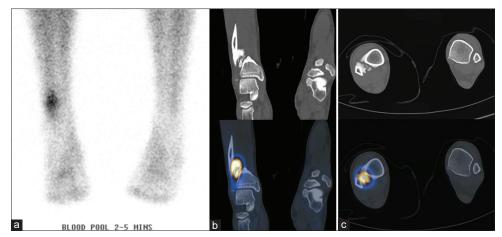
The patient continued to have persistent symptoms and triple-phase dynamic bone imaging with technetium 99m-methylene diphosphonate was performed to direct further management. (a-c) Both blood pool and bone phase imaging revealed intense focal tracer activity. The localization to heterotopic ossification centered on the heterotopic ossification of the tibiofibular syndesmosis was best seen with single-photon emission computed tomography/computed tomography indicating ongoing osteoblastic turnover in the region. There was no scintigraphic evidence of occult fracturing
